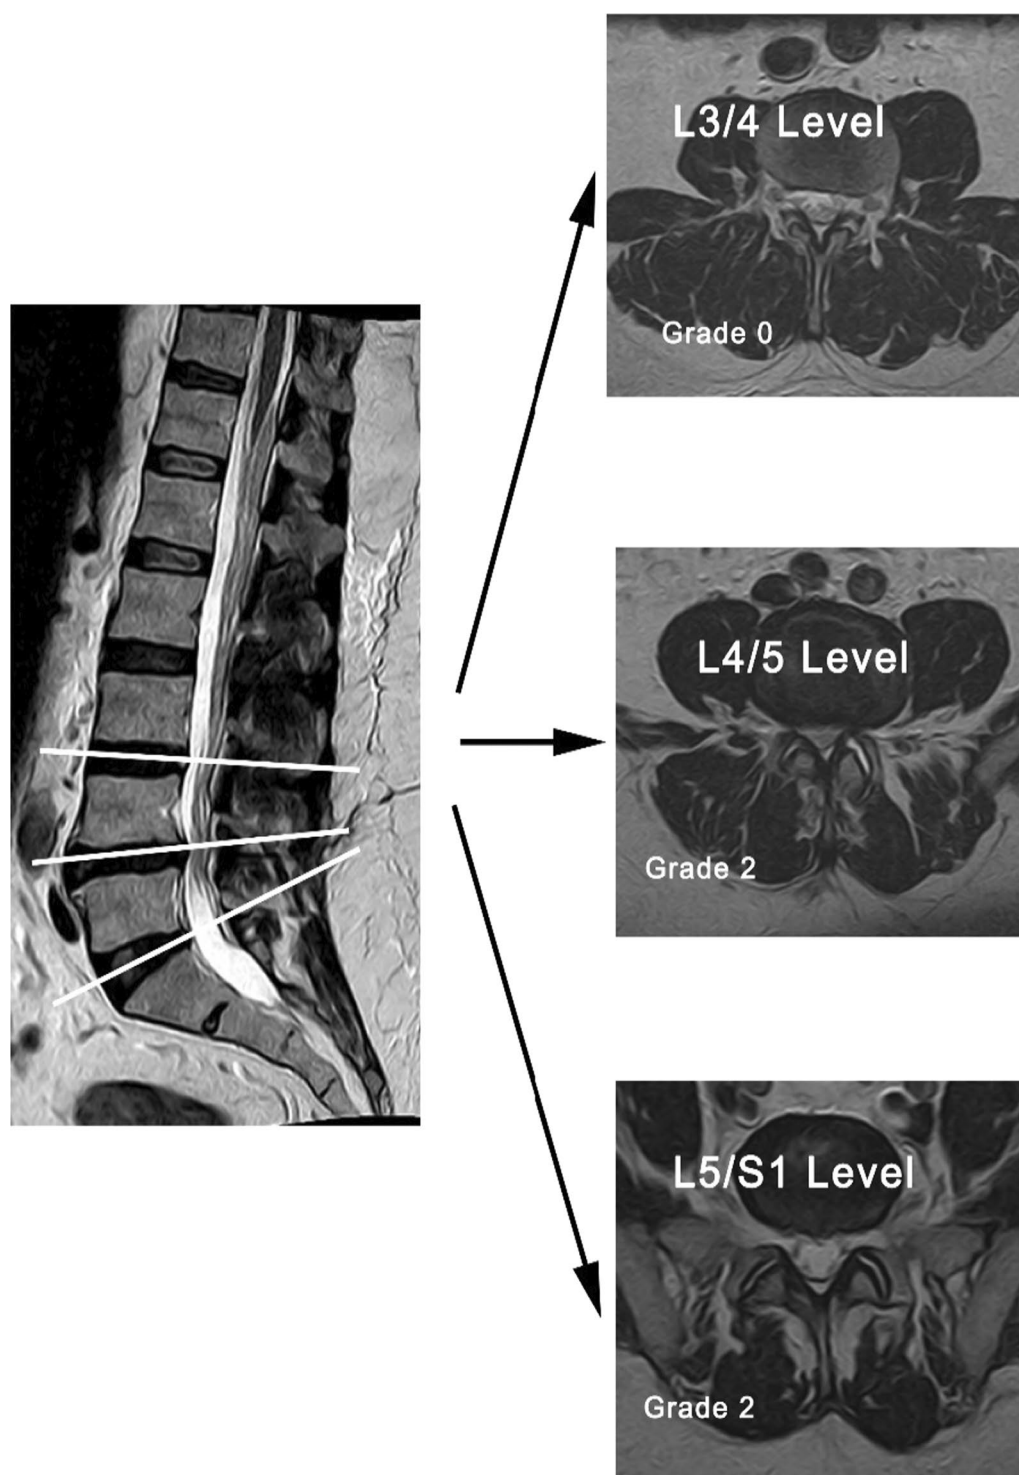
Lumbosacral MRI, of a 57-year-old man with 5 years history of LBP without sciatica, BMI = 18, there is disc bulge at L4/5 and L5/S1 levels. No neural canal stenosis. Average VAS score = 5. Axial cuts revealed grade 0 MS degeneration at L3/4 level, grade 2 MS degeneration at L4/5 and L5/S1 levels, MS = 4. $MS = 1.154 + (0.017 \times \text{Age}) + (0.184 \times \text{duration years}) + (0.081 \times \text{Sciatica}) + (0.287 \times \text{VAS})$. According to MS equation, the expected MS = 4.5
